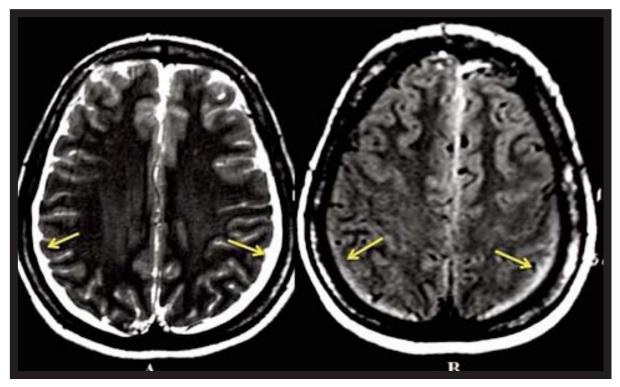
T2-weighted (A) and FLAIR (B) transverse images show hyperintensity of thickened dura and subdural effusion on both hemispheres (arrows).
